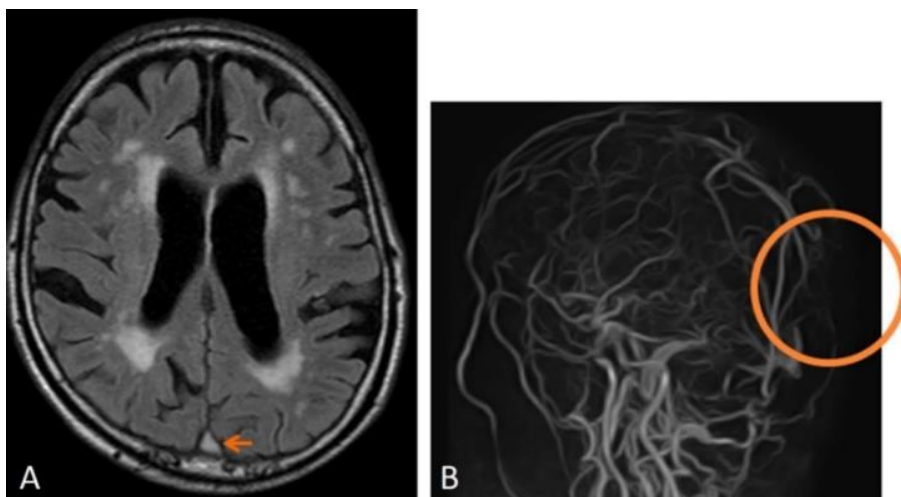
MRI with FLAIR (A) and MRV (B, in circle).
